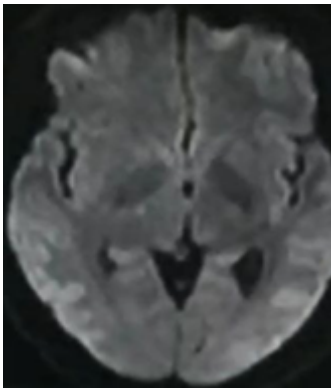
(Diffusion weighted image (DWI))
